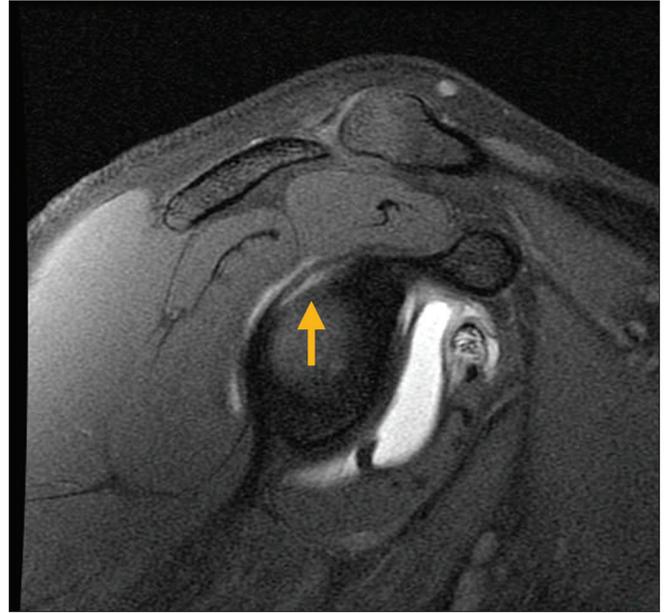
Sagittal T1-weighted magnetic resonance arthrography image with fat saturation demonstrating high signal in the posterior superior labrum, which is consistent with a tear (arrow).
